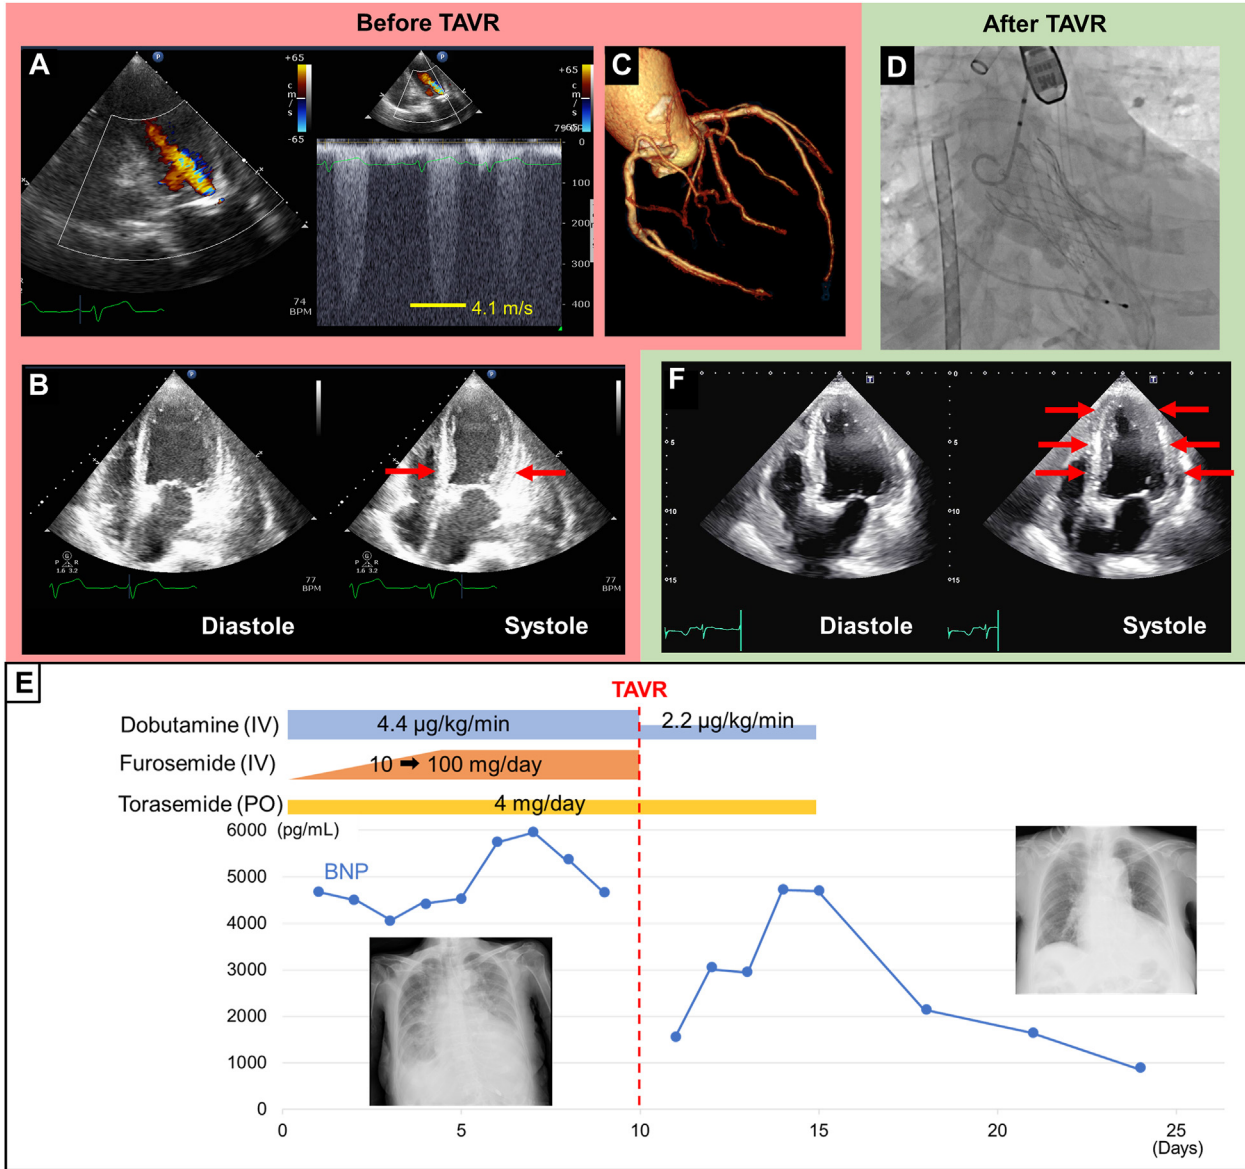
Transcatheter aortic valve replacement (TAVR) for Takotsubo cardiomyopathy. (A) Apical 3-chamber views demonstrating a calcified aortic valve with regurgitation (left) and a transaortic peak velocity of 4.1 m/s (right). (B) Apical 4-chamber views demonstrating Takotsubo-like left ventricular apical hypokinesis (arrows). (C) Coronary computed tomography demonstrating no coronary stenosis. (D) TAVR was performed without complications. (E) One week after TAVR, brain natriuretic peptide (BNP) levels decreased and inotropes and diuretics were discontinued. (F) Normalized left ventricular wall motion after TAVR (arrows). IV, intravenous; PO, per os.
